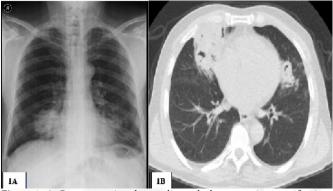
A. Posteroanterior chest radiograph demonstrating opacifications and infiltrations paracardiac right lower and left lower zone B. Computed tomography scan of the thorax demonstrating right lower and left lower lobe consolidation
